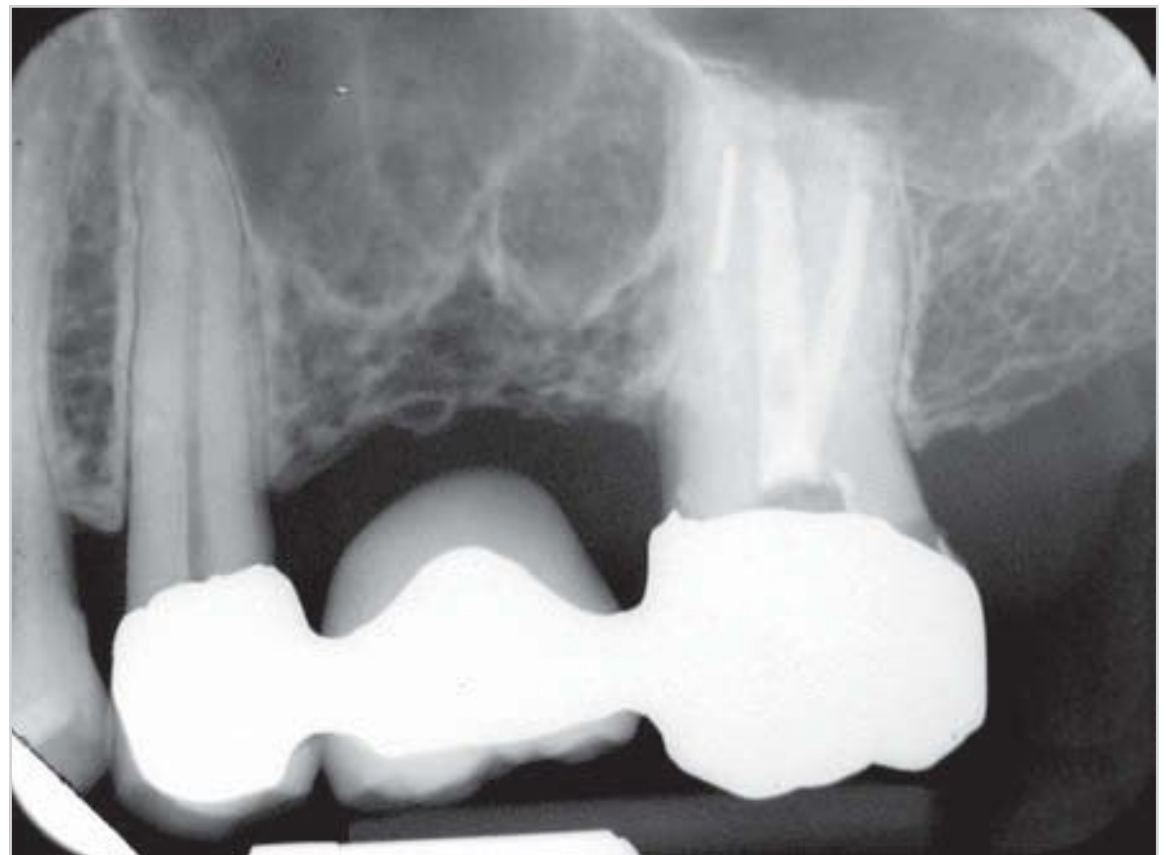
Correct maxillary periapical radiograph of the entire tooth.
